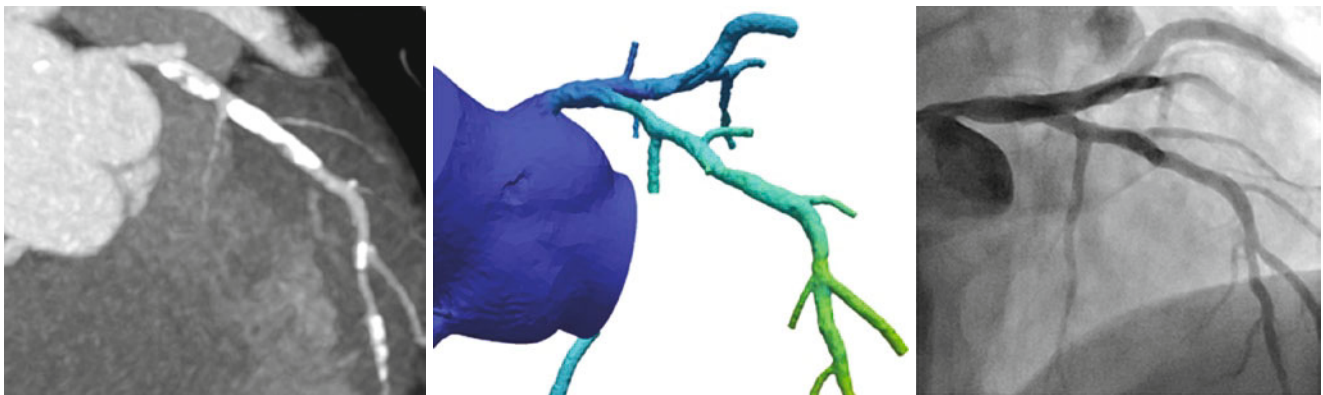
These images are from a 61-year-old man with an estimated 30–49% stenosis of the right coronary artery in coronary CTA. However,  $FFR_{CT}$  measured 0.64, suggestive of ischemia. Quantitative invasive coronary angiography measured a 76% stenosis, with a similarly low FFR
